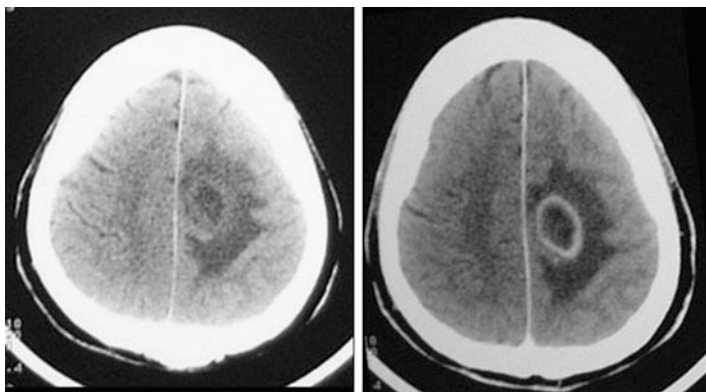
Pre and post contrast CT scan showing a left parietal ring enhancing lesion with surrounding edema (low density area). Stereotactic aspiration showed a Nocardia brain abscess
